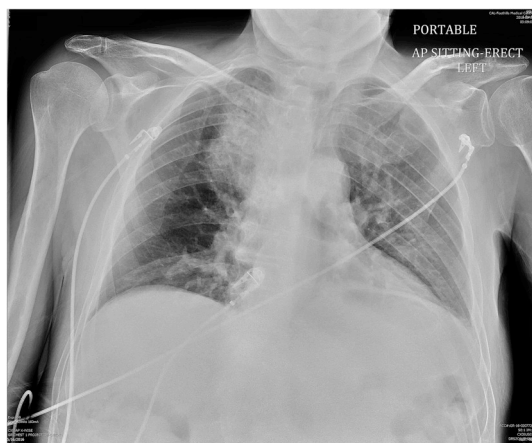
Chest X-ray on admission: right upper lobe airspace disease and consolidation.
